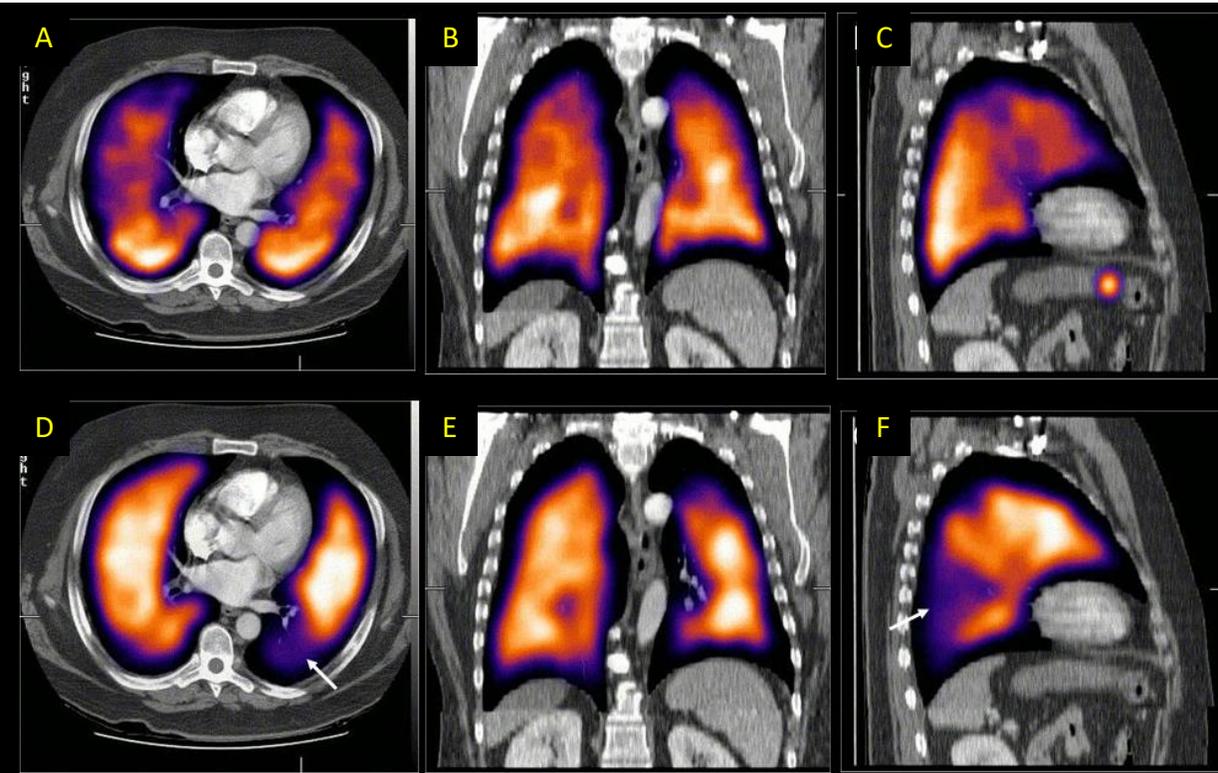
State of the art contemporary SPECT/CT imaging of lung ventilation (top row) and perfusion (bottom row) in three orthogonal planes. The fusion SPECT/CT images demonstrates a segmental perfusion defect (arrow in 7D and 7F) in the left lower lobe. This appears mismatched when compared with the corresponding ventilation images. The “notch” at the apex of the left lung seen in the sagittal views (7C and 7F) is matched on ventilation and perfusion and therefore is unlikely to be due to an embolus.
